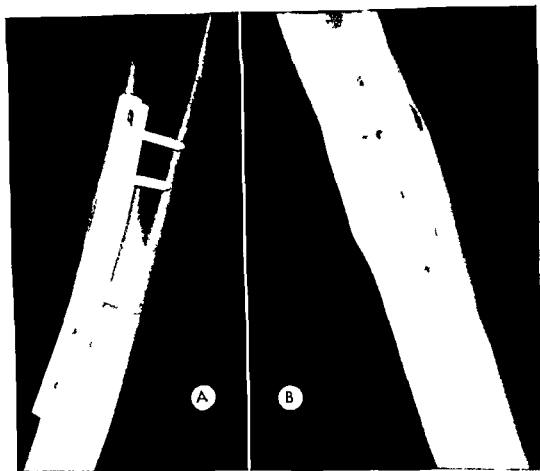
(A) This radiograph of a plated femoral shaft shows sound union and reformation of the medullary cavity. Severe local pain and tenderness necessitated removal of the implants. (B) Radiograph following removal shows dense sclerosis around each screw hole.
